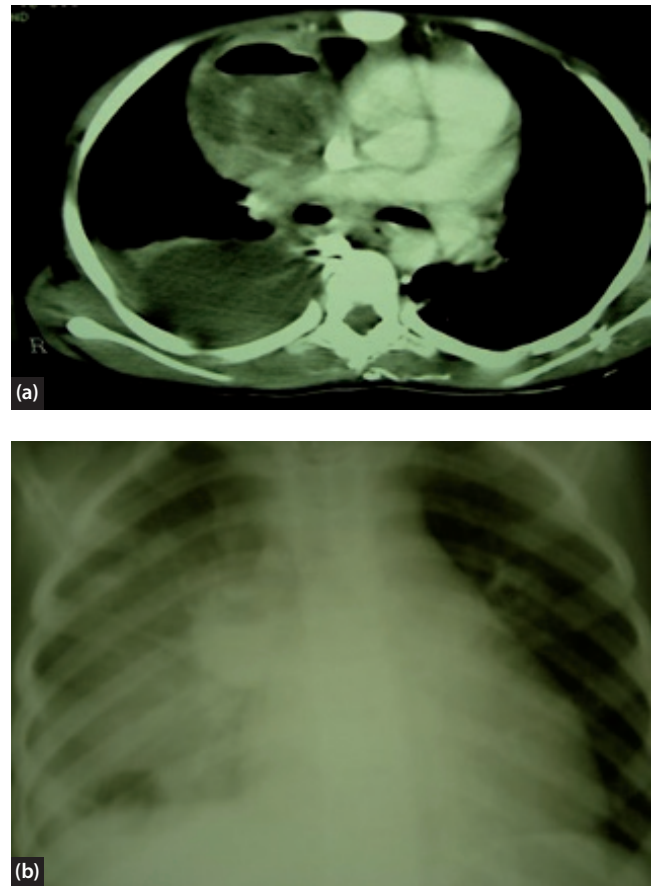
CT scan and chest X-ray demonstrating a lung abscess secondary to septic emboli from internal jugular vein thrombosis.
